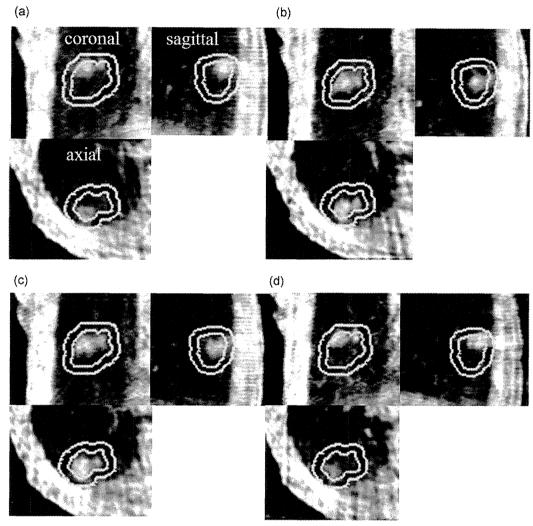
4D CBCT images acquired during VMAT delivery on the first day to verify the in-treatment moving tumor position in reference to the PTV and ITV contours. In this case, the number of phase bins was four, which covered an entire breathing cycle.
